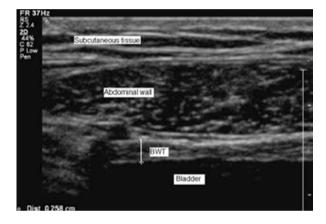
Ultrasonographic measurement of BWT of the anterior bladder wall (Silva 2015-Needs permission Silva 2015)
